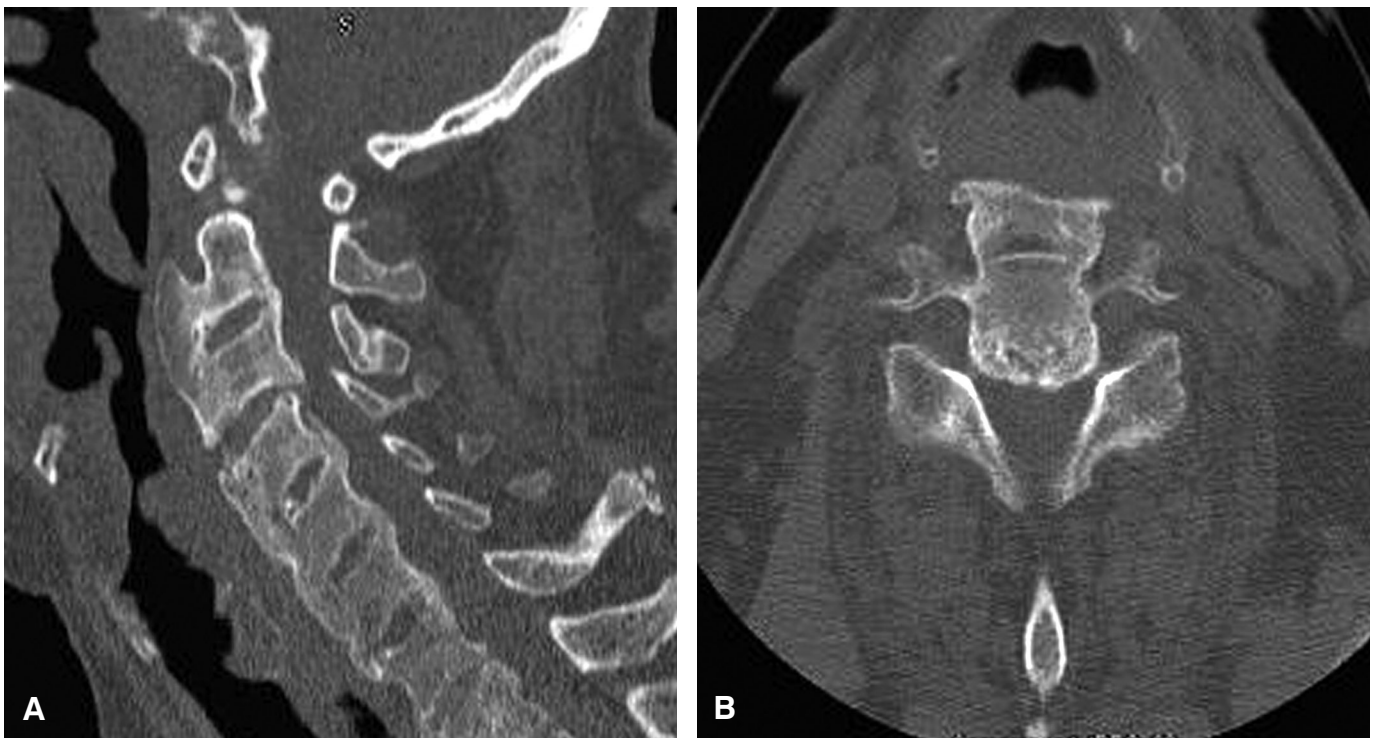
(A) Sagittal and (B) axial CT scans of the cervical spine show either diffuse skeletal hyperostosis or ankylosing spondylitis; both conditions have a similar appearance on CT studies. Ossification of the anterior and posterior longitudinal ligaments is associated with severe osseous ridging along the spine. Hyperostotic changes contribute to the severe stenosis of the spinal canal.
